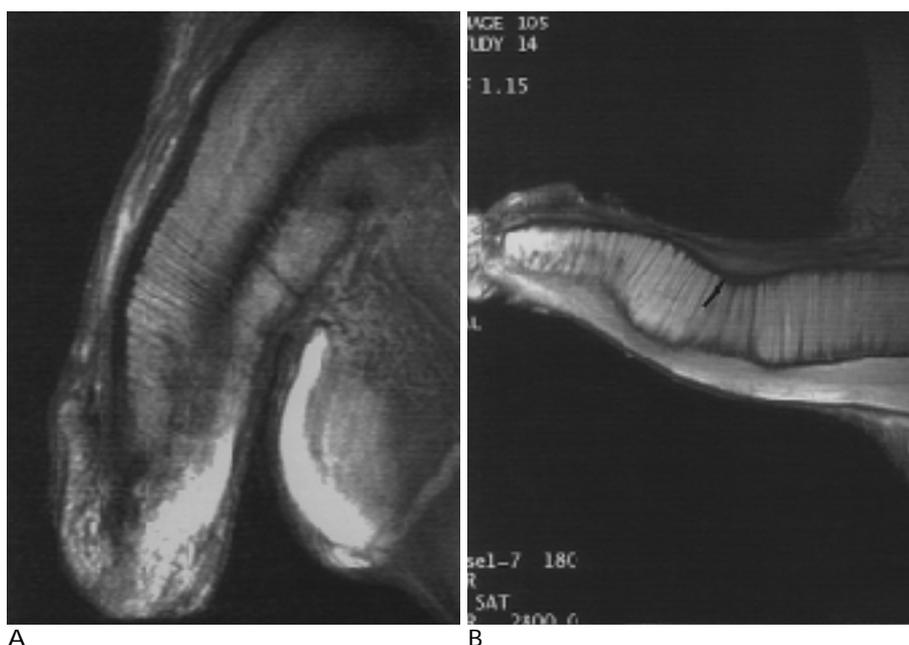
Sagittal penile MR images in a 50-year-old man who has Peyronie’s disease and palpable plaque.
